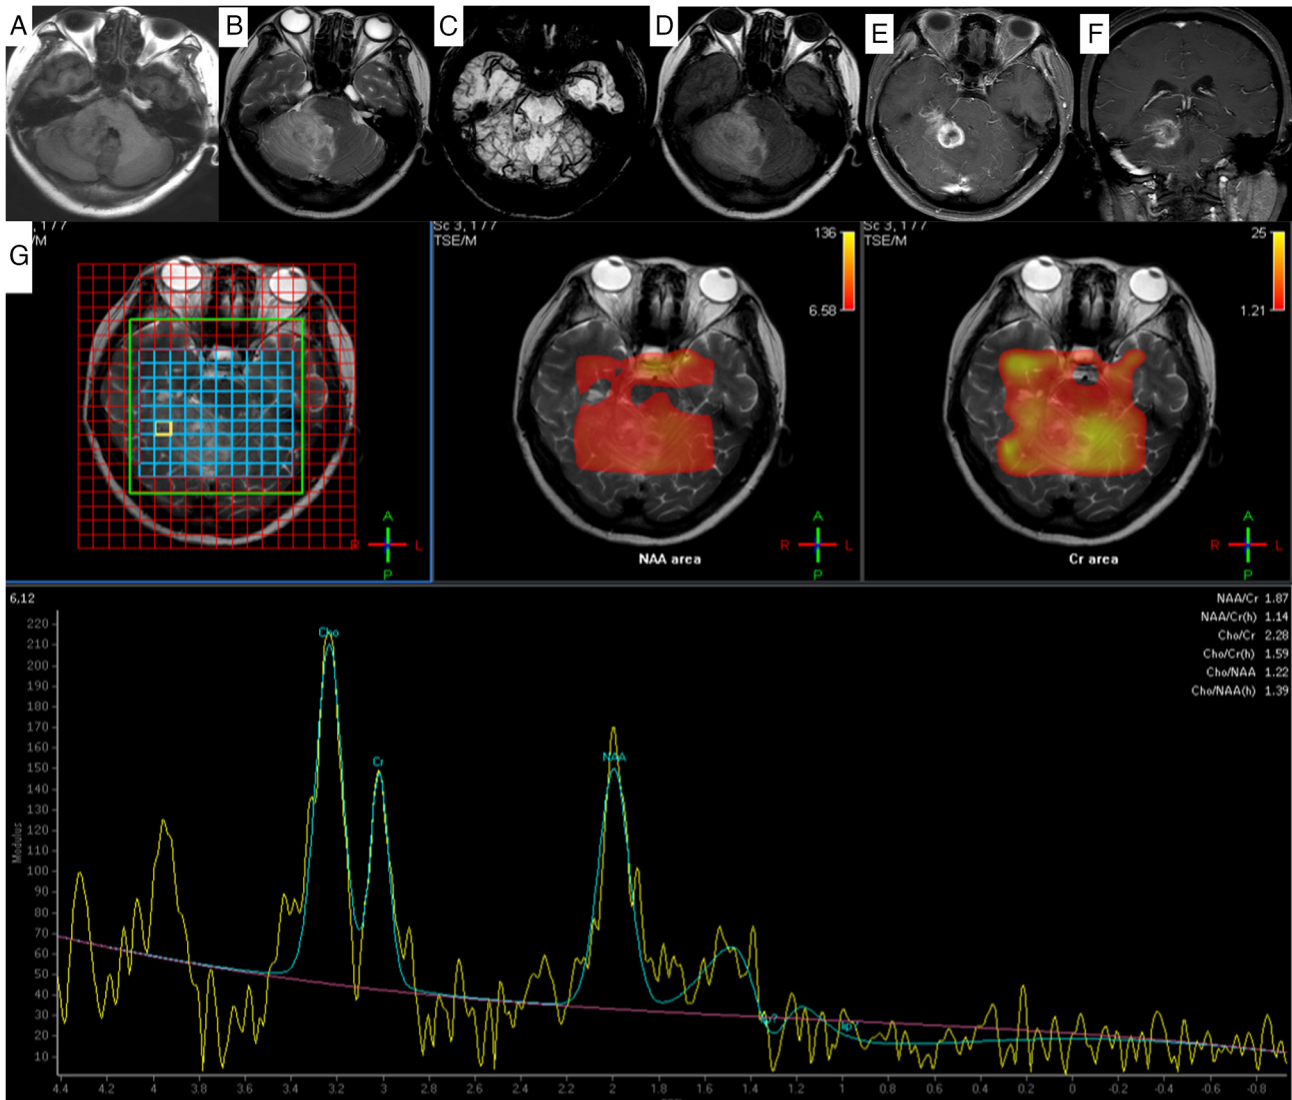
Magnetic resonance imaging findings of gliosarcoma in the right cerebellar hemisphere and right parahippocampal region. (A) In the right cerebellar hemisphere and right parahippocampal region, patchy slightly hyperintense and isointense signals on T1-weighted imaging were observed. (B) On T2-weighted imaging, slightly hyperintense signals were noted, mixed with small patchy slightly hypointense signals. (C) Susceptibility-weighted imaging demonstrates punctate hypointense foci within the lesion. (D) Fluid-attenuated inversion recovery imaging shows hyperintensity. The lesions exhibited obvious inhomogeneous enhancement on (E) axial and (F) coronal images. The lesion involves the right portion of the brainstem and cerebellar vermis, with compression of the adjacent fourth ventricle and brainstem. (G) The peak value of NAA in the lesion area was decreased, the peak value of Cho was significantly increased, and the peak value of Cr remained basically unchanged. MRI, magnetic resonance imaging; NAA, N-acetylaspartate; Cr, creatine; TSE/M, turbo spin echo/magnetization.
